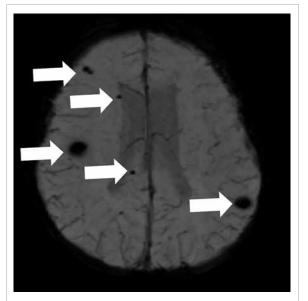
Magnetic resonance imaging axial susceptibility weighted image showing additional foci demonstrating susceptibility artefacts (arrows) in bilateral cerebral hemispheres, compatible with multiple cavernoma
